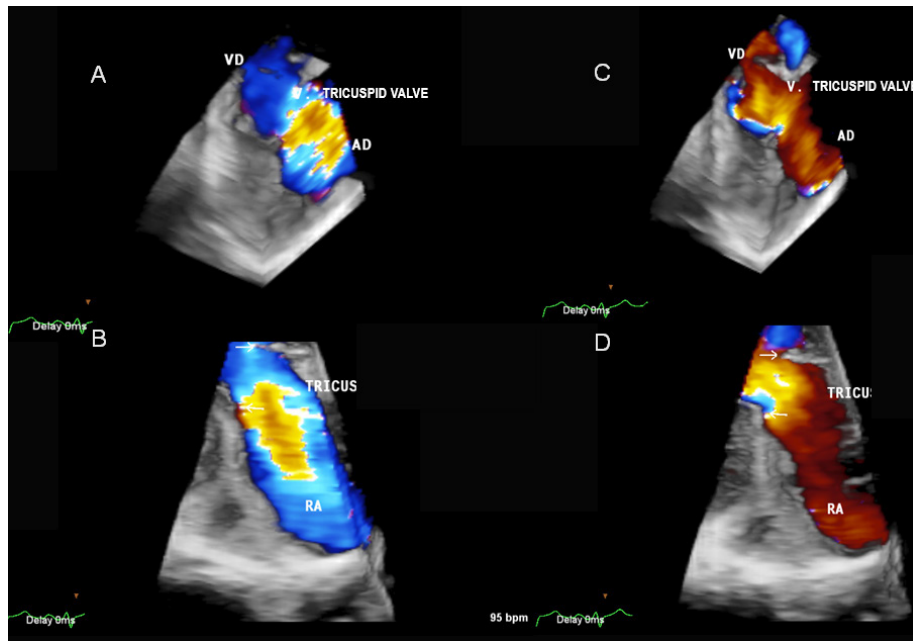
Real-time three-dimensional transthoracic echocardiography with tricuspid valve flow mapping with color Doppler showing fixed leaflets (arrows) and laminar flow during systole (A and B) and during diastole (C and D). Severe grade tricuspid regurgitation without stenotic component.
